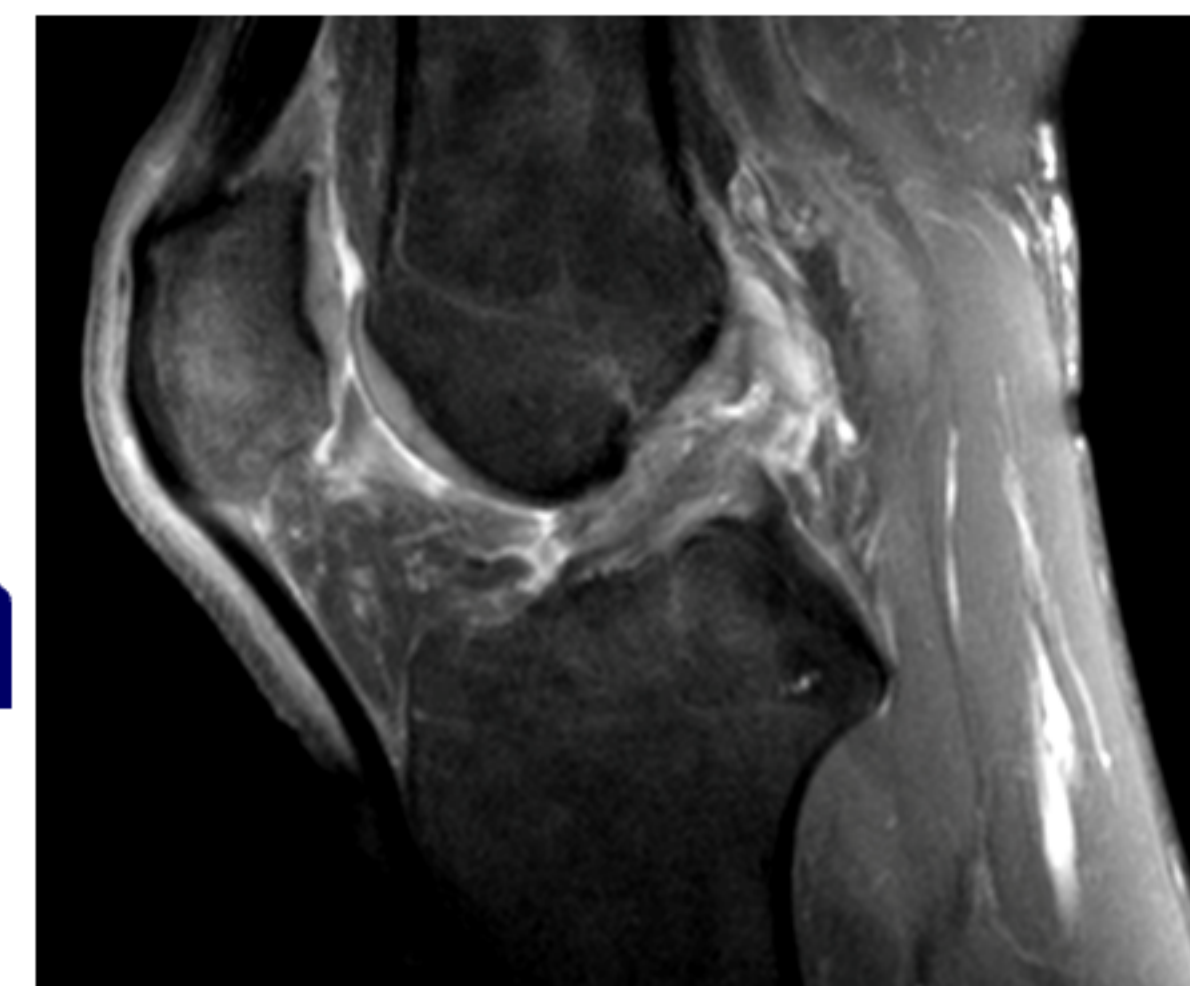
Sagittal T2 MRI showing complete proximal third mid-substance ACL tear
